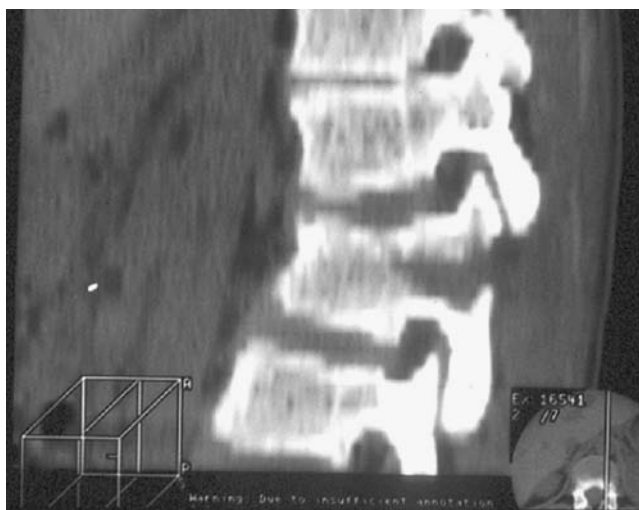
Magnetic resonance imaging scan of the lumbar spine of a 12-year-old girl involved in a high-speed motor vehicle collision. An anterior compression of L2 is seen, with disruption of the posterior elements. The lap belt complex in this patient also included loss of her small bowel secondary to thrombosis of the superior mesenteric artery.
